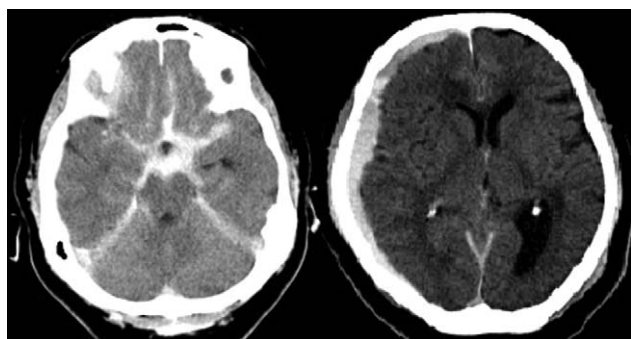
Computed tomography performed 1.5 hours after percutaneous coronary intervention revealed massive subarachnoid hemorrhage and acute subdural hematoma.
